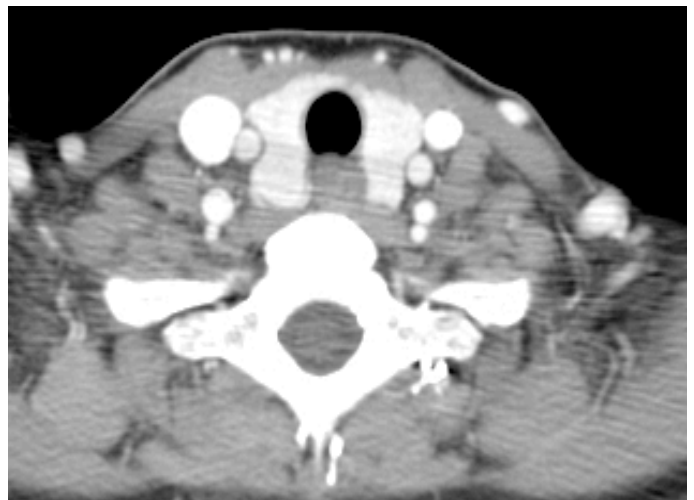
Follow up CT performed 12 months later showing complete resolution of the thyroid lesion and some bilateral lymph nodes the largest is 14 mm in size. No other soft tissue abnormality is seen.
